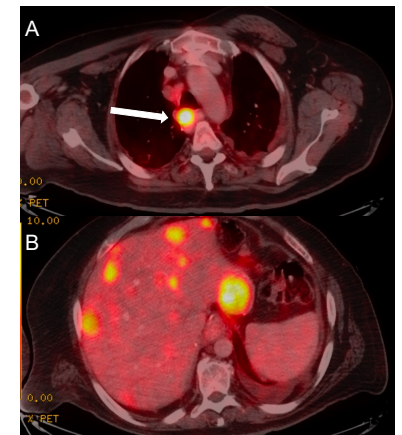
A: Postoperative PET scan demonstrating an FDG-avid paraesophageal lymph node (arrow) B: Postoperative PET scan demonstrating extensive FDG-avid liver metastases
